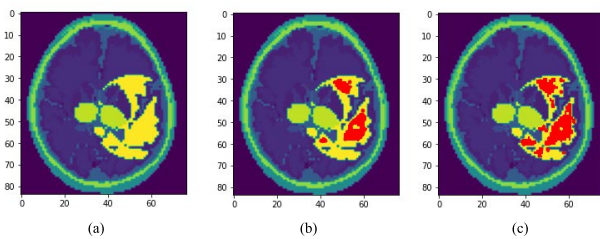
Anomaly localization. (a) Segmented pathological MRI image. (b) Localization of classical approach (detected anomaly is red). (c) Localization of EPT approach (detected anomaly is red).
